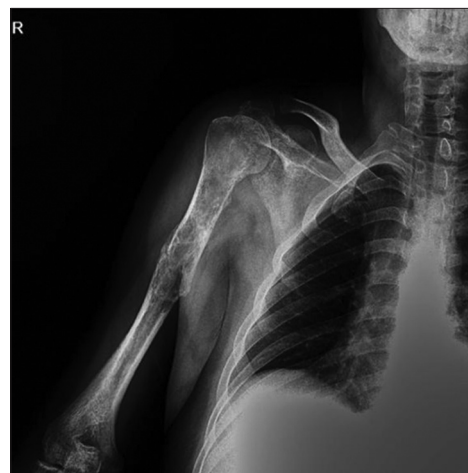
Post-operative X-ray of the right arm
